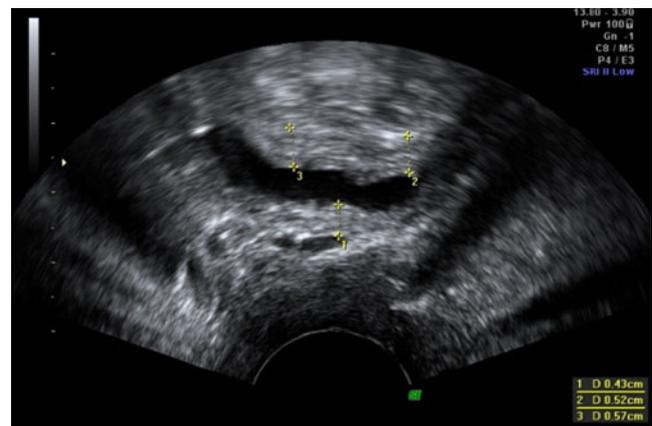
Two-dimensional transvaginal ultrasound image of BWT measurement. Measurements are taken at the trigone (1), anterior wall (2) and dome (3) of the bladder
